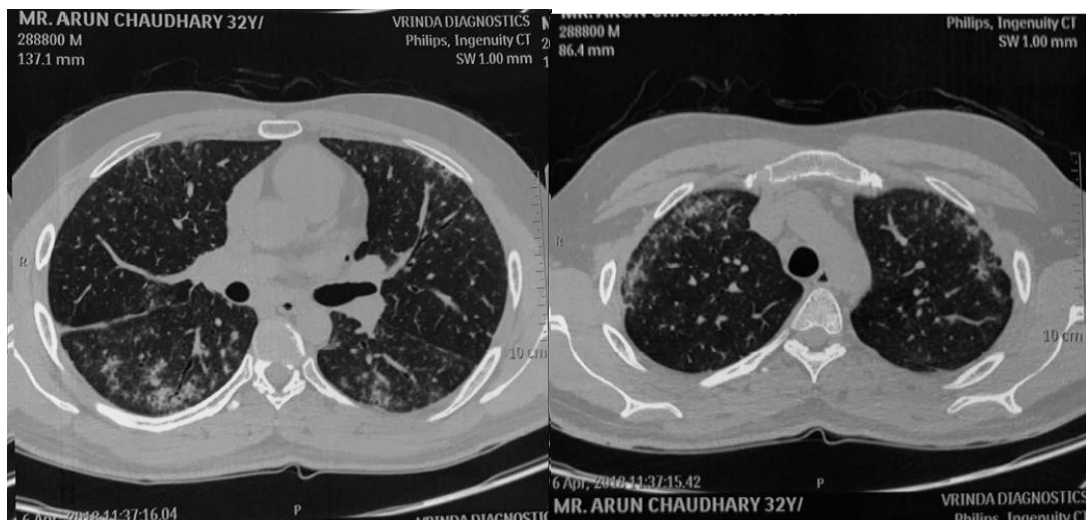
High-resolution CT scan (lung window) shows a visceral pleural plaque in the right major fissure, bilateral curvilinear bands of subpleural reticular hyper-attenuating areas
